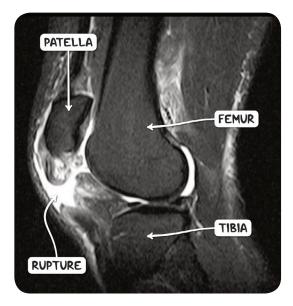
An MRI scan of the knee in the sagittal plane demonstrating a patellar tendon rupture
